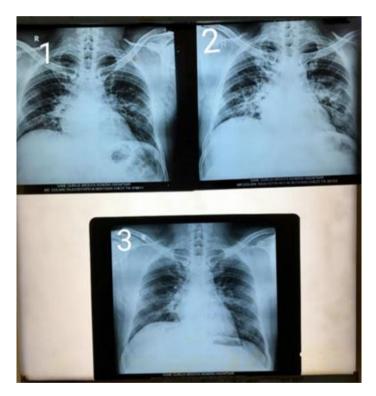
Chest X-ray Assessment during Treatment
